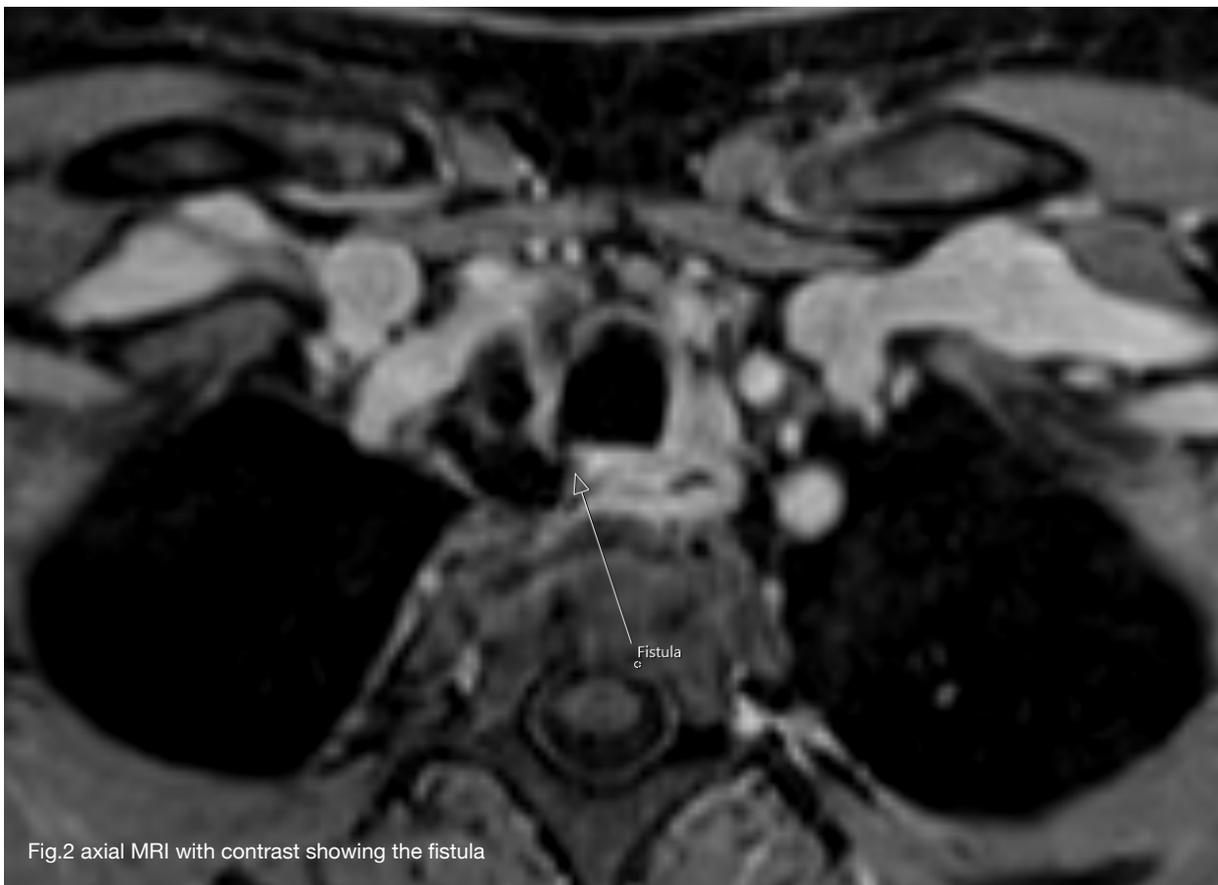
axial MRI with contrast showing the fistula
